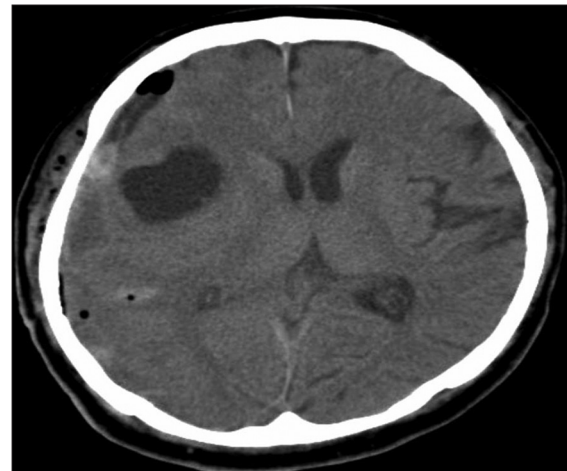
Axial noncontrast CT brain done postoperatively shows a 'subarachnoid cyst' in right frontal lobe likely communicating with the Sylvian fissure and remnant SDH
